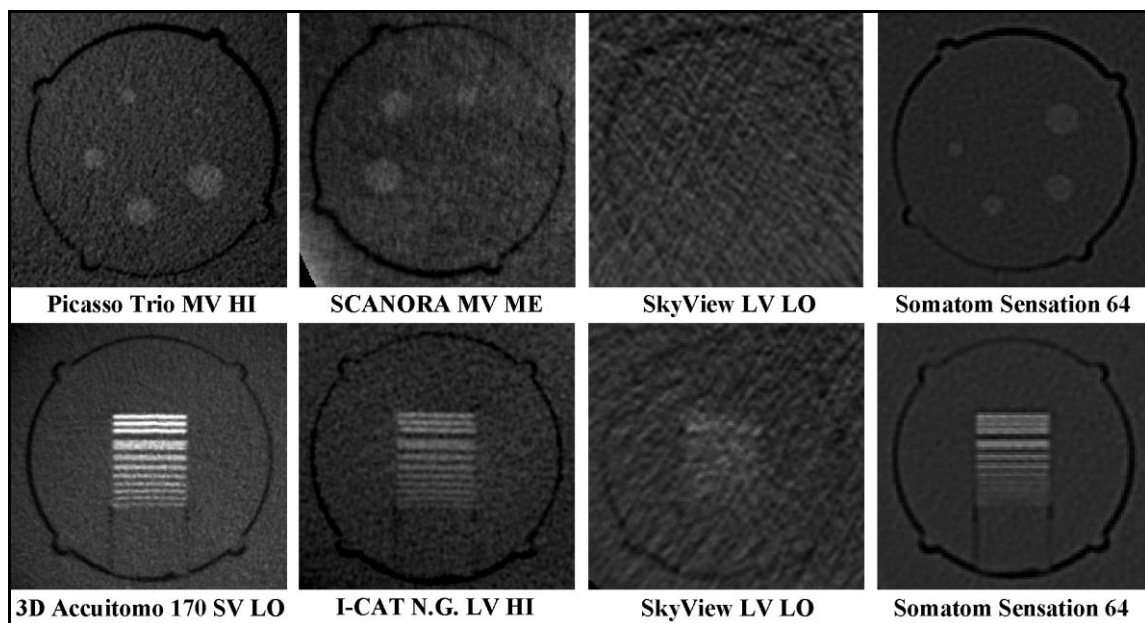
Example slices of line pair and rod inserts. The HA200 rod insert (top row) and the axial line pair insert (bottom row) are shown. The best scoring (first column), median scoring (second column) and worst scoring (third column) CBCT protocols were selected for each insert, as well as the MSCT H60s protocol (right column).
